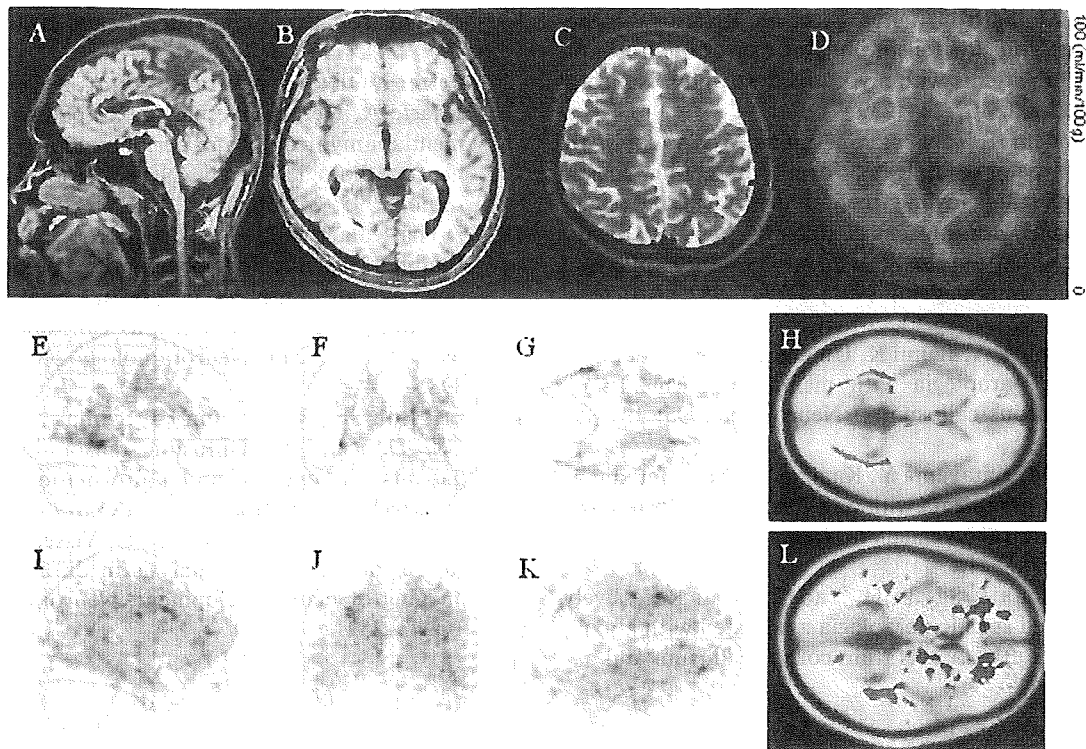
Patient 2, 17-year-old younger brother with familial spastic paraplegia. A: Sagittal T₁-weighted image showing thin corpus callosum (CC), particularly in the anterior half. B: Axial T₁-weighted MR image shows relatively preserved cortex. The trigone of the left lateral ventricle is slightly dilated. C: Axial T₂-weighted magnetic resonance (MR) image shows no abnormal signals. D: Single photon emission computed tomography (SPECT) image shows hypoperfusion in the left occipital cortex, both frontal cortices and thalami, and the left striatum. E-H: The decreased region of fractional anisotropy (FA) value depicted on the standard normalized space (2-sample t-test, statistical parametric mapping [SPM] 2). Significantly low FA value was detected in the entire cerebral white matter, especially the optic radiations. I-L: The increased region of MD value is shown. Significantly high MD was revealed, similar to the findings in Patient 1.
